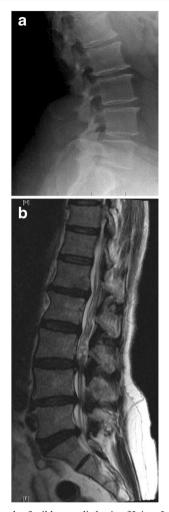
a Radiograph of mild anterolisthesis of L4 on L5 in the setting of degenerative discovertebral and facet joints. b. The sagittal view of T2 MRI showing spinal stenosis. Note the disc protrusions and hypertrophic ligamentum flavum.
